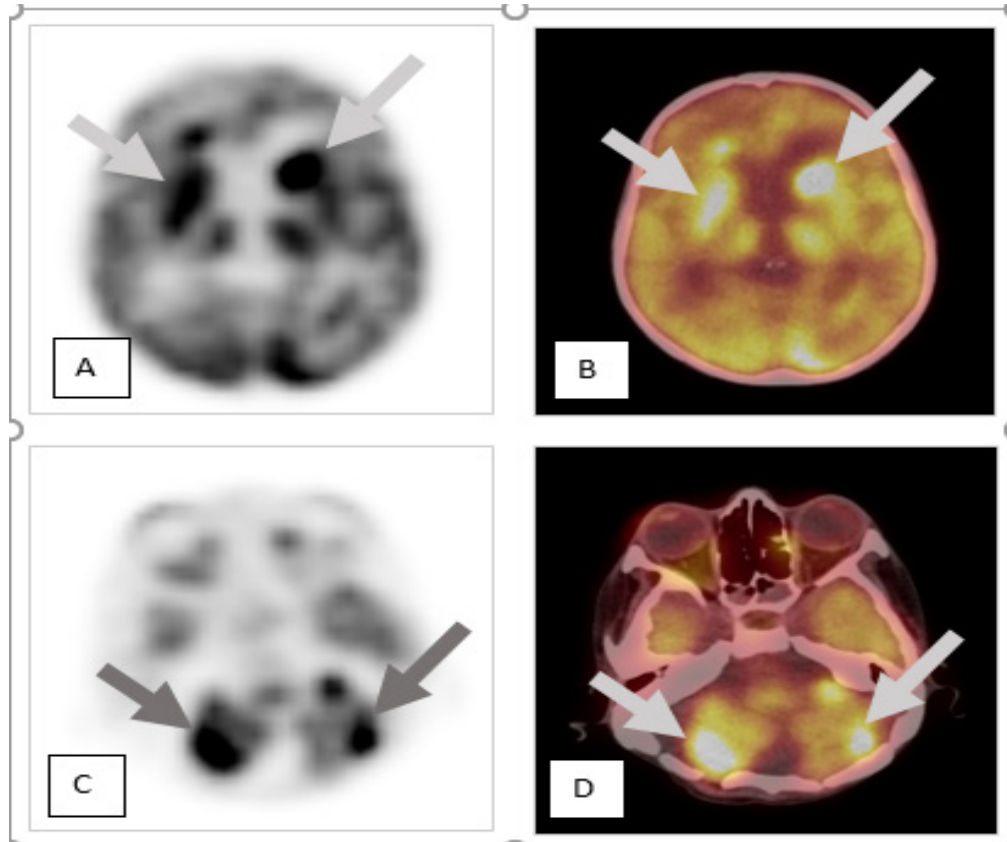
18-F FDG PET/CT axial brain showed multiple intensely 18-F-FDG avid hypermetabolic lesions in the supra-tentorial periventricular area (A&B) and infra-tentorial bilateral cerebellar (C&D) in keeping with known metastatic lesions.
